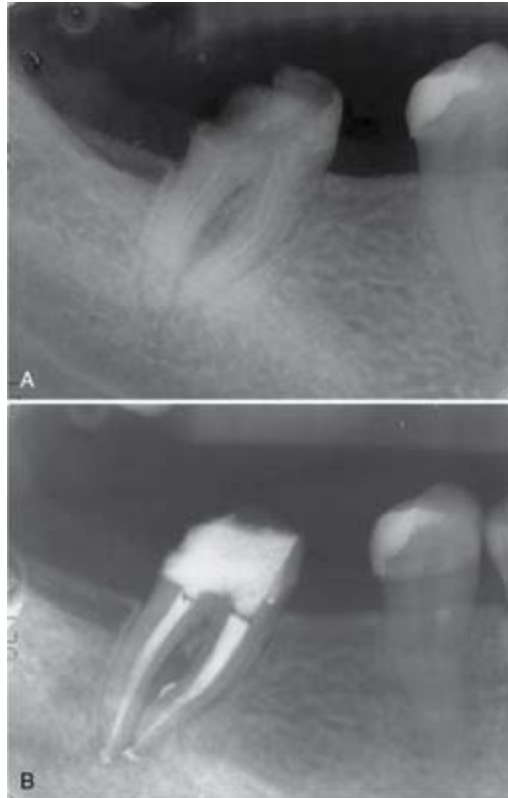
A, Tooth #31 with three separated files, one in each canal. K-files used for cleaning canals and also obturation (1996). B, No apparent radiographic changes in 1998.
